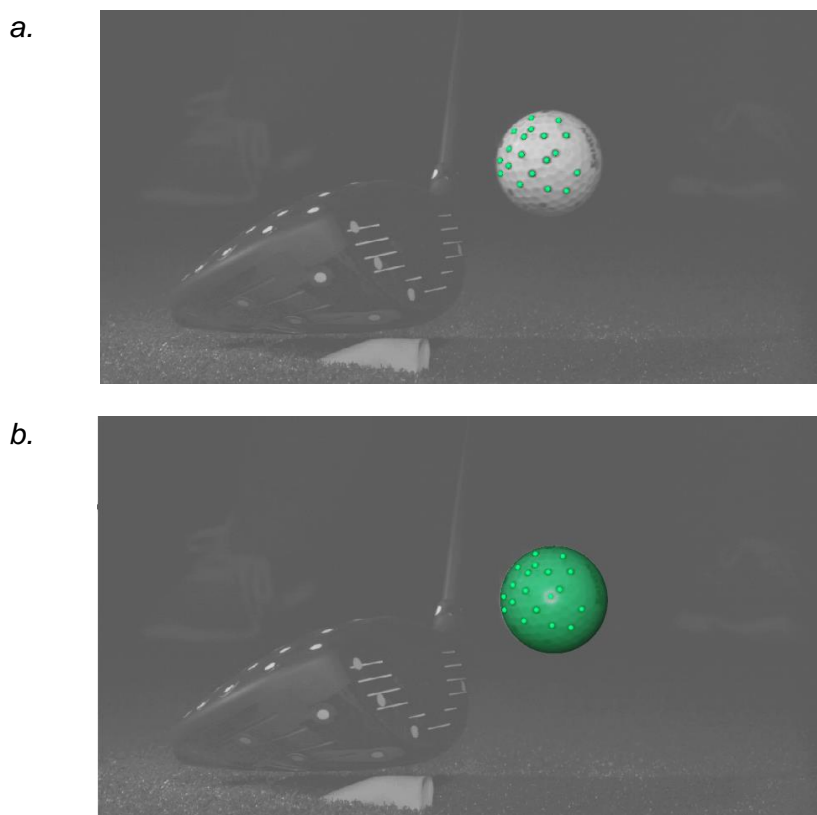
Sphere fitting to the tracked ball surface points in GOM INSPECT involving a. the identification of the points and b. a sphere of best-fit of radius 21.3 mm fitted to the points.
